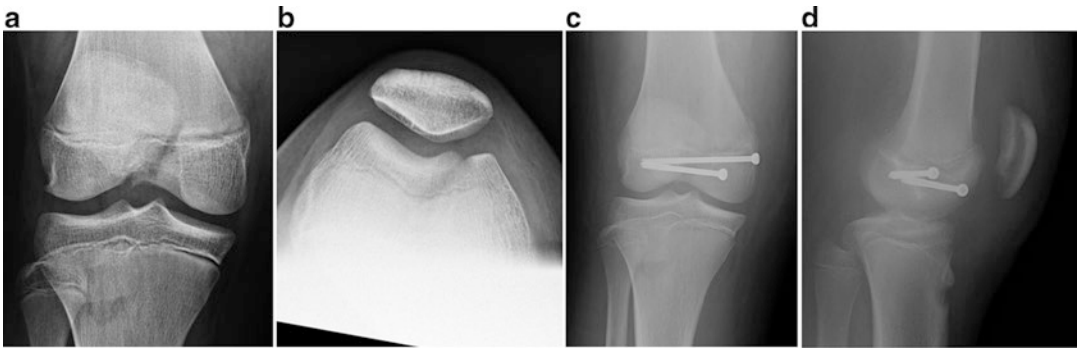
(a–d) AP and lateral radiograph images from the same patient as in Fig. 12.2 demonstrating screw fixation just distal to physis and proximal to intercondylar notch
